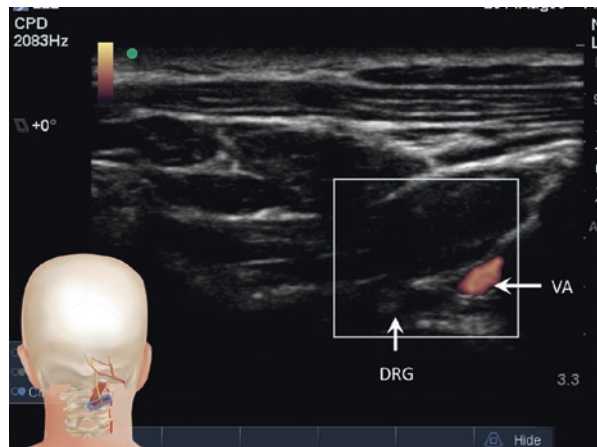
By moving the probe further in the lateral direction as in Fig. 2.5 and applying the Doppler, it revealed the vertebral artery (VA) and the dorsal root ganglion (DRG). (Reprinted with permission from Philip Peng Educational Series)
